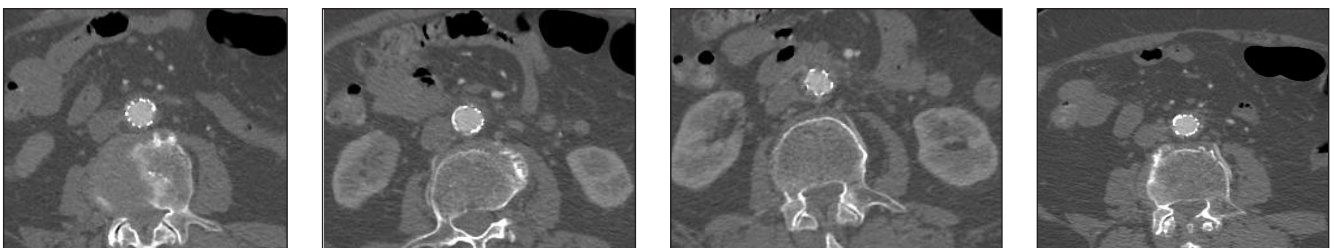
CT scan after stent placement showing no residual stenosis.
